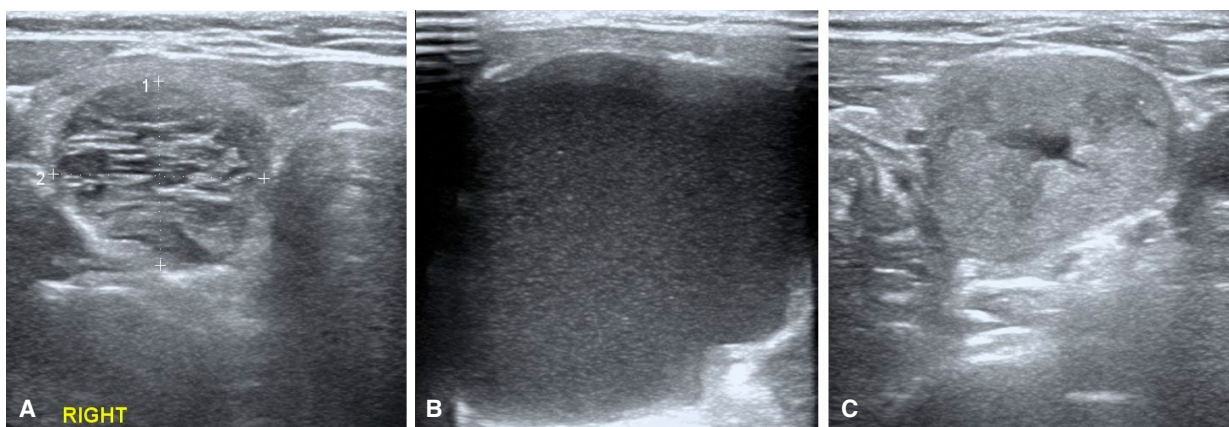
Ultrasound image showing examples of benign thyroid nodules. TIRADS 2 (A) spongiform, (B) cystic; TIRADS 3 (C) mixed predominantly solid isoechoic nodule.
